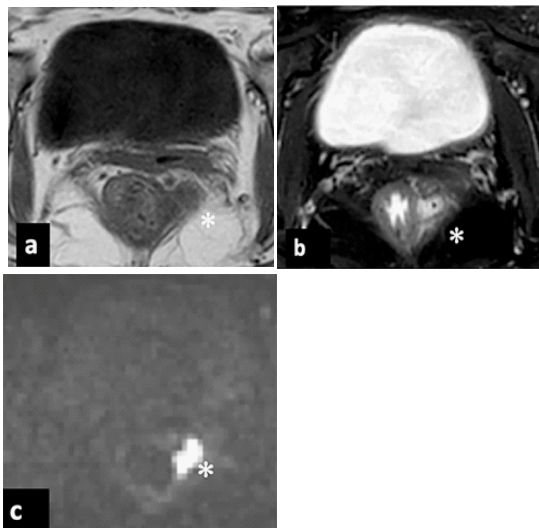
(a) MRI axial T1 sequence shows hypointensity on the left side of the rectal fat. (b) MRI T2 axial with fat suppression shows hyperintensity of the left para-rectal fat, in the lower rectum, compatible with inflammatory changes and associated collection (asterisk). (c) Diffusion-weighted imaging corroborates the findings on T2.
